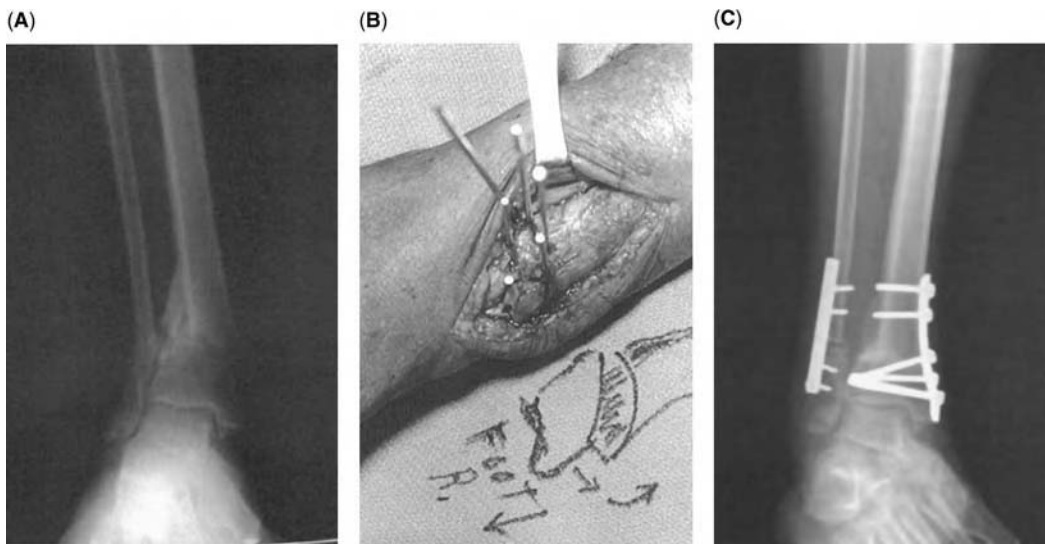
(A) Preoperative radiograph of a 60-year-old woman with a two-year history of distal tibial malunion after nonoperative treatment. (B) Dome osteotomy for valgus deformity. (C) Postoperative view at 12 weeks with the patient weightbearing.
